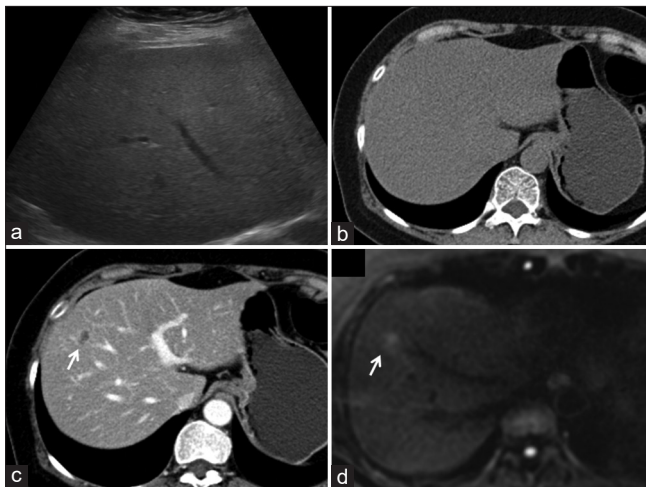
A 58-year-old woman affected by breast cancer. The lesions missed with ultrasound (a), noncontrast-enhanced computed tomography (b) and detected with contrast-enhanced computed tomography (c) (white arrows, 4 mm) at S8 of liver. The lesion showed diffusion restriction on liver magnetic resonance imaging (d)
